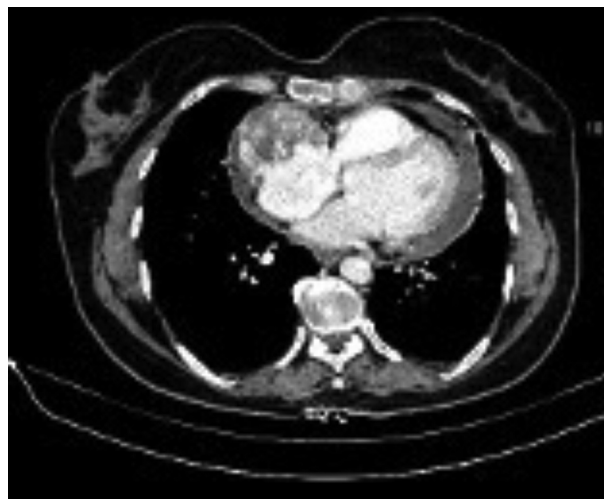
Preoperative computed tomography showed a right atrial mass.
